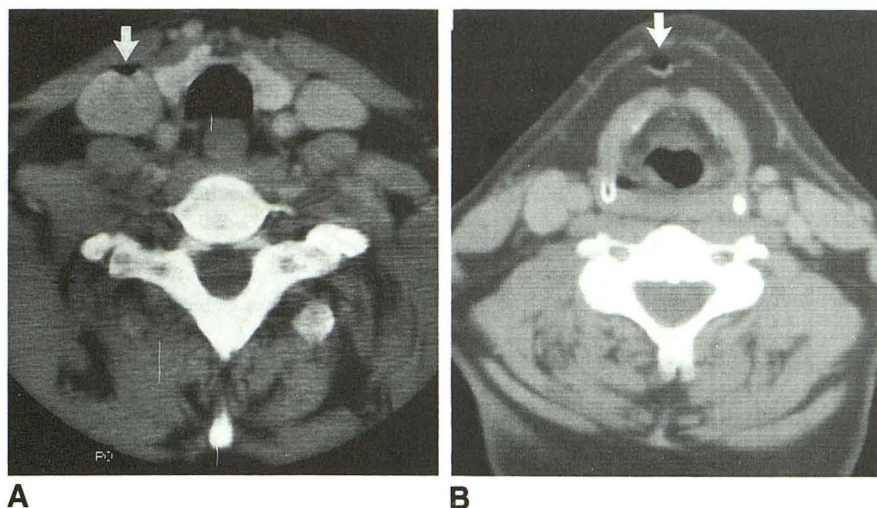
Gas (arrows) in the right internal jugular vein (A) and in an anterior neck vein (B) after the injection of intravenous contrast through a peripheral intravenous line started for this neck CT. The scan was performed to evaluate a suspected neck mass.
